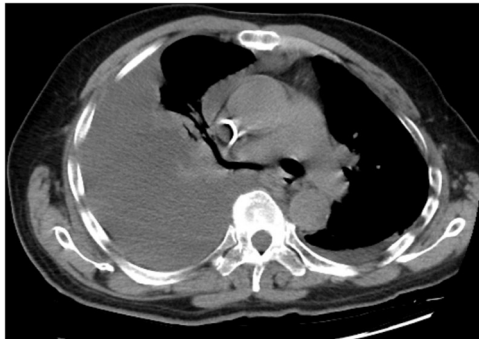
Computed tomography of the chest revealed Large right pleural effusion nearly fills the right thoracic cavity.
